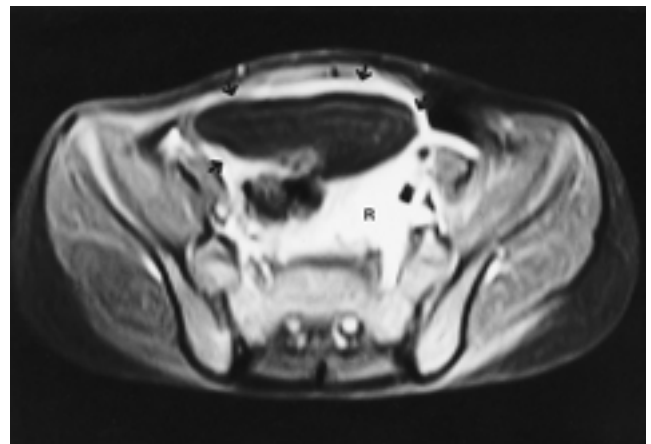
Gd-DTPA enhanced axial MR image after chemotherapy shows residual tumor (R) and diffusely thickened wall of the urinary bladder (arrows).
